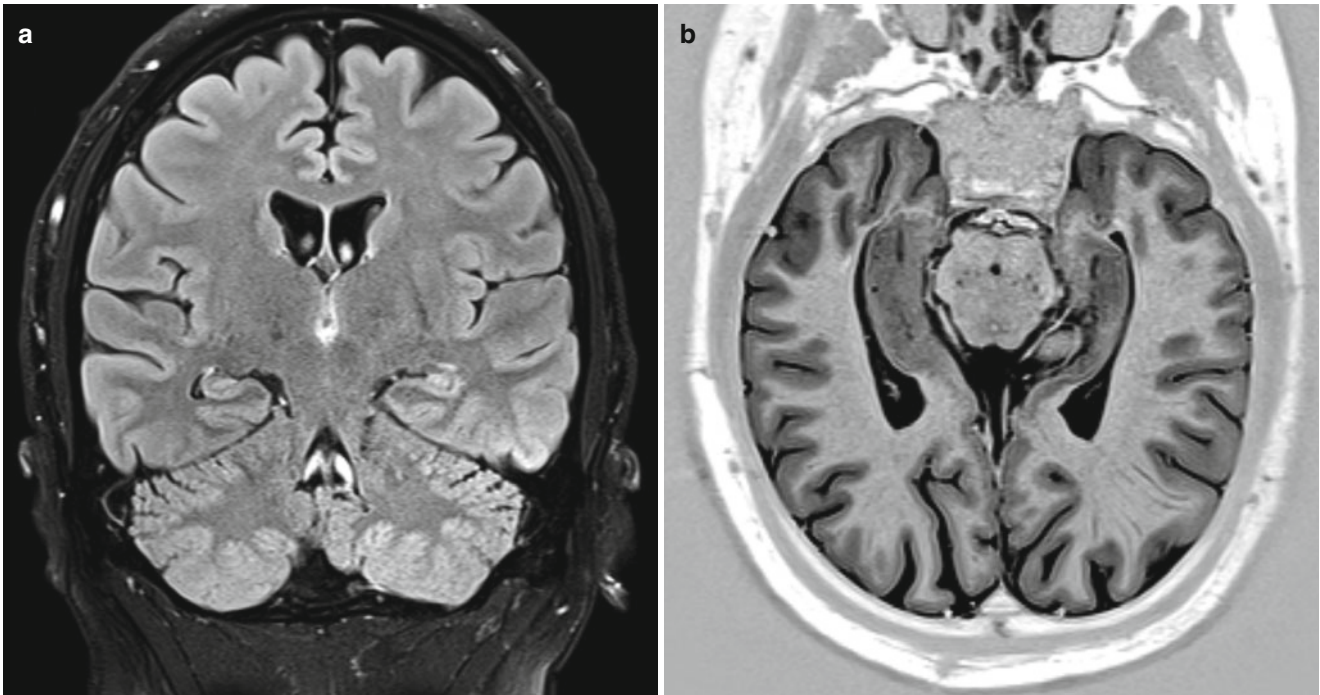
(a, b) Mesial temporal sclerosis (MTS): (a) coronal T2/FLAIR shows increased signal in the left hippocampus; (b) axial T1 IR demonstrates volume loss in the left hippocampus. The findings shown are
